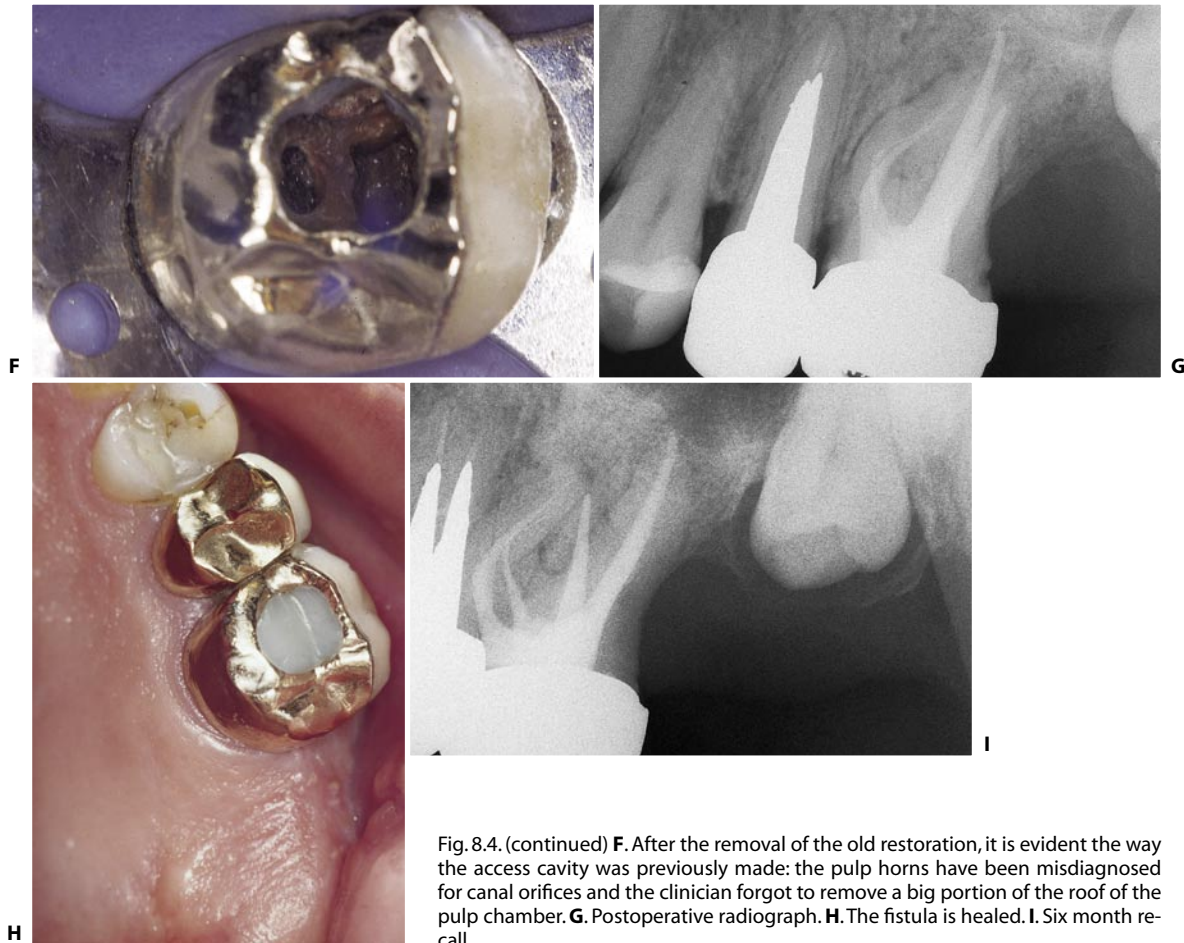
(continued) F. After the removal of the old restoration, it is evident the way the access cavity was previously made: the pulp horns have been misdiagnosed for canal orifices and the clinician forgot to remove a big portion of the roof of the pulp chamber. G. Postoperative radiograph. H. The fistula is healed. I. Six month recall.
